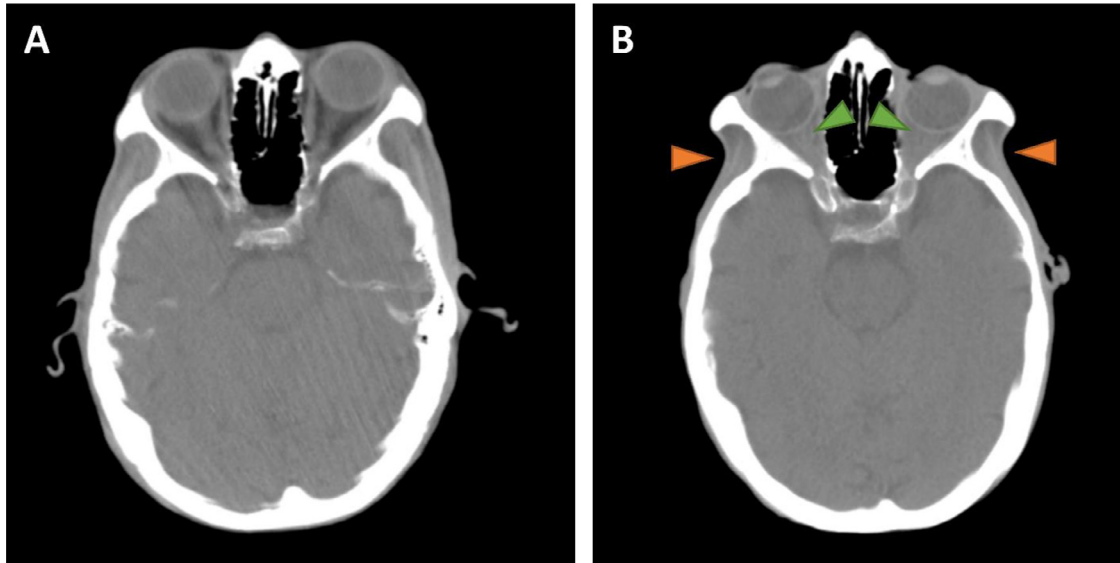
Head CT performed on hospital day 2 (A) is presented on soft-tissue window and demonstrates a normal volume of retrobulbar orbital fat, subcutaneous fat, and a normal temporalis muscle. In contrast, a head CT performed on hospital day 28 (B) following a complicated hospital course including multiple resuscitations, bowel perforation, and total colectomy reveals a marked interval reduction in orbital fat resulting in enophthalmos (green arrowheads) and significant volume loss in the temporal fossae (orange arrowheads).
